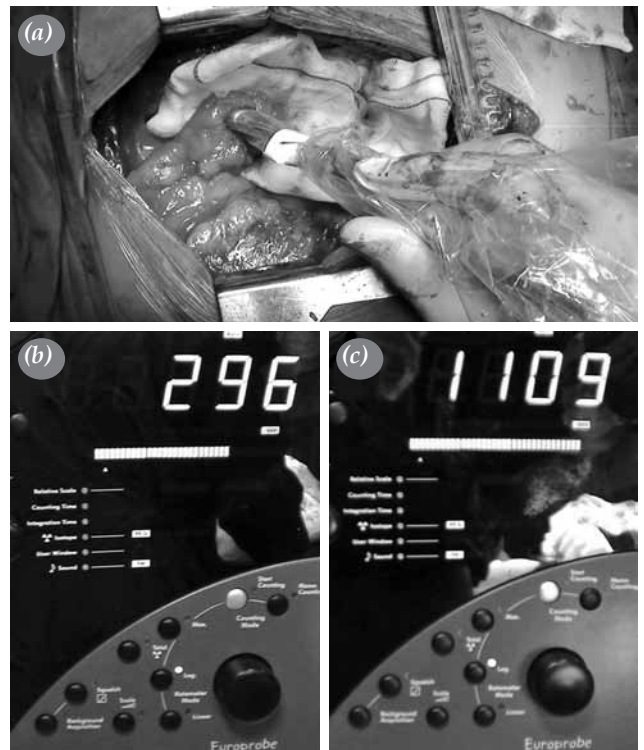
(a) Radioactivity count was obtained from surgical area. (b) Lower counts were obtained from normal tissues. (c) Higher counts were obtained from region consistent with focal activity accumulation on parathyroid scintigraphy.
